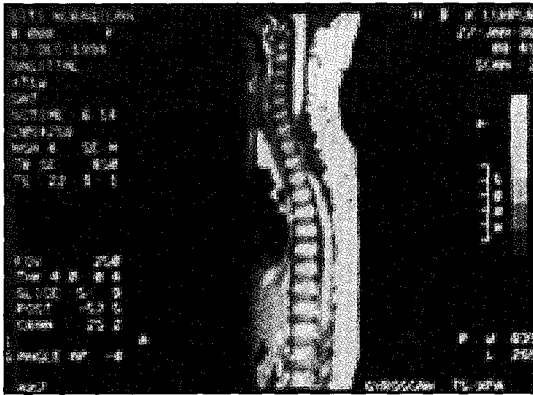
MRI films showing the presence of an epidural haematoma from C7 to T6.
